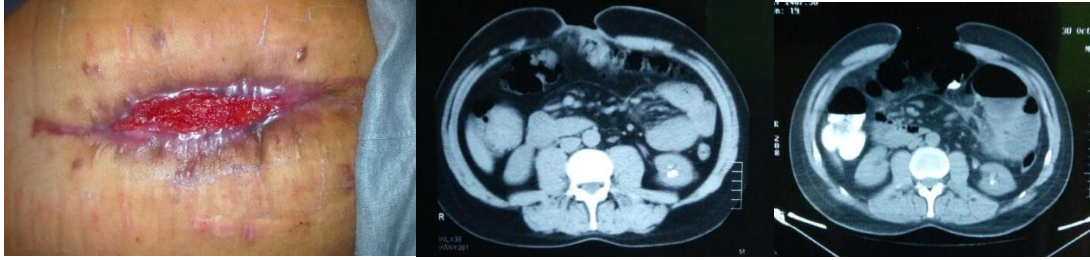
CT image of open abdomen on day 1 (left image) & day 10 (middle image) using SVB. Wound appearance on day 18 (right image).
